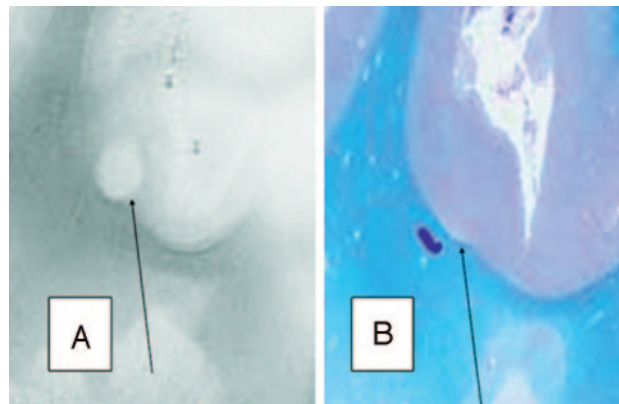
A, SE T2-weighted image, TR = 750 ms, TE = 20 ms, FOV = 15 cm, matrix = 1024 \times 1024, and section thickness = 1 mm.
